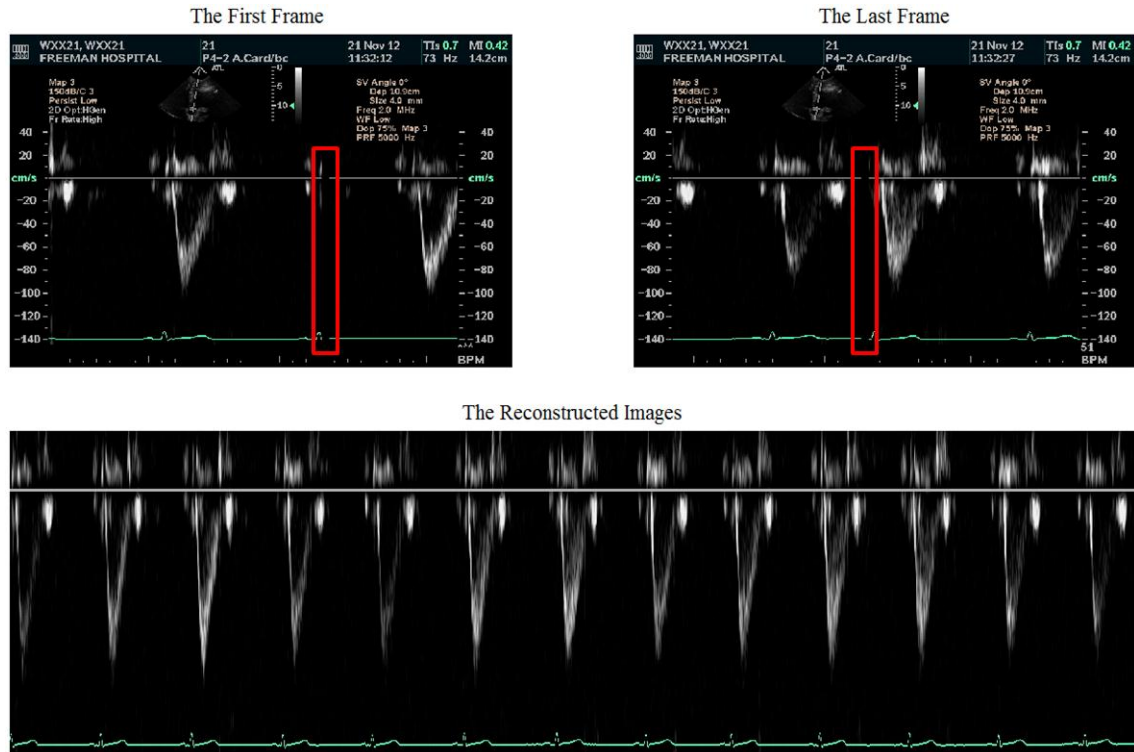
An example of reconstructing a pixel series of a Doppler image. The first frame and the last frame are shown in different screens in the original image. However, all frames were displayed on a single screen in the reconstructed image. During reconstruction, the annotation part in the original images was removed.
